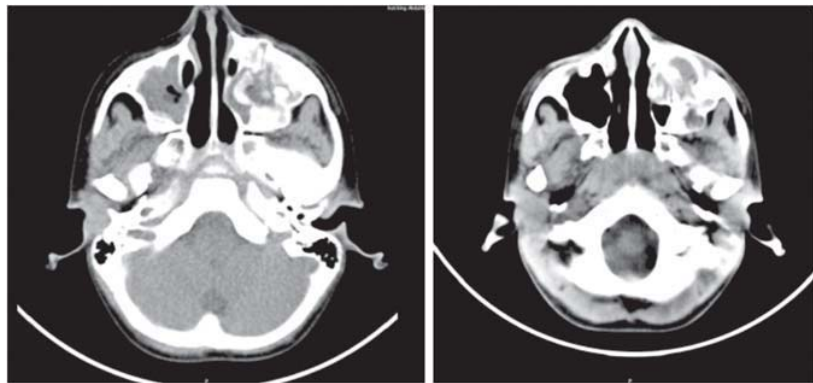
(a) Axial CT showing bony regeneration 6 months post curettage with thick radio-opaque margin (b) Axial CT showing recurrence of mixed radiolucent and radio-opaque lesion a year later
